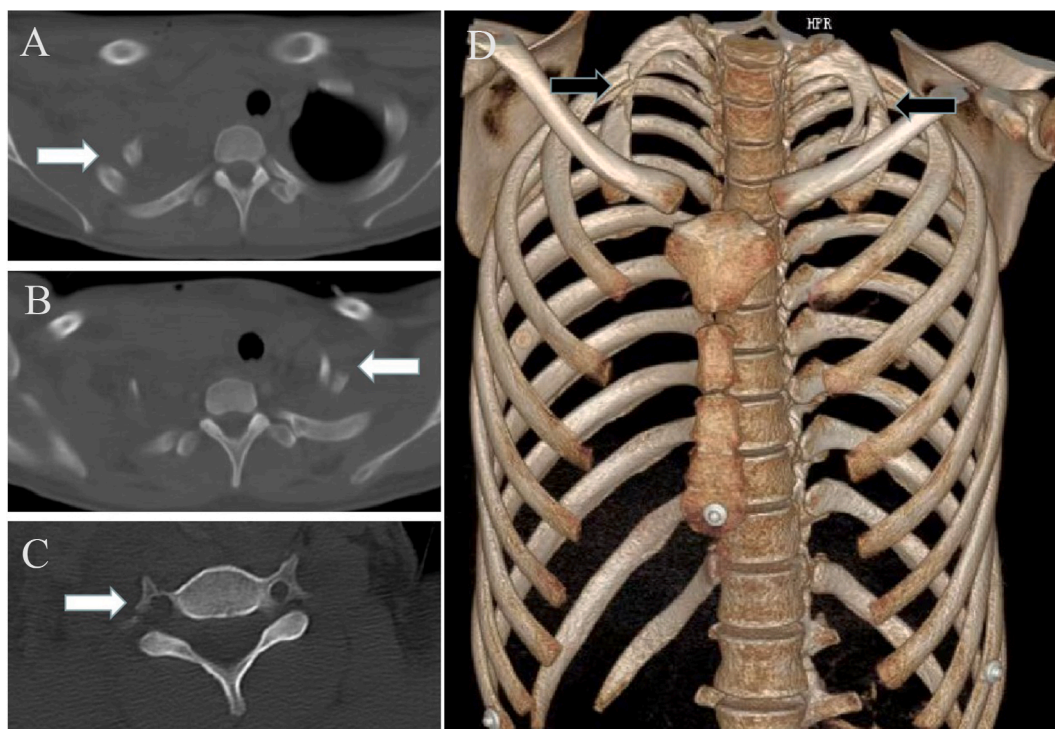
Images of bilateral first rib fractures and transverse process fracture of the 6th cervical vertebra. A and B. The neck and chest CT showed fractures of the right and left first rib respectively (white arrow). C. The neck CT showed a transverse process fracture of the 6th cervical vertebra (white arrow). D. Three-dimensional CT of the neck and chest confirmed bilateral first rib fractures (black arrow) and the displaced fractures of the right first rib with a jagged edge.
